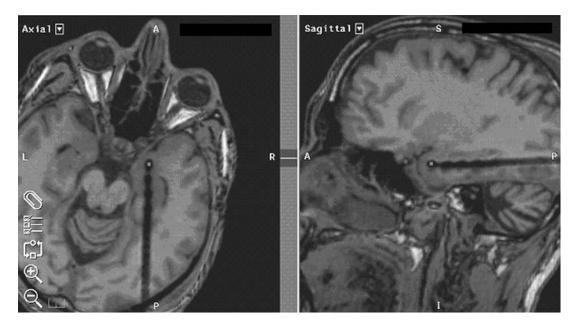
Postoperative T1-weighted MRI with an implanted electrode for AHCS
